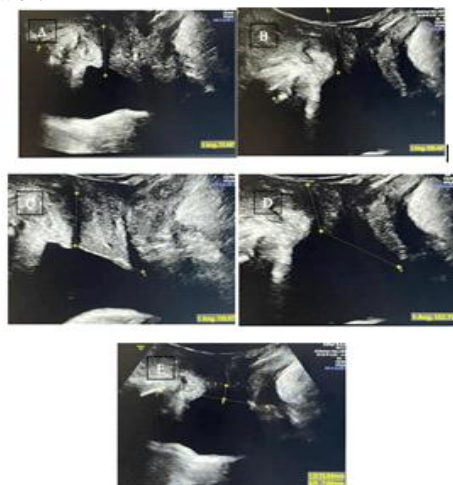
Transperineal ultrasonography (USG) in the midsagittal section. (A) Alpha angle at rest (73°). (B) Alpha angle during strain (102°). (C) Beta angle at rest (102°). (D) Beta angle during strain (132°). (E) The bladder descent during strain measured 7.89 mm from the reference line drawn between the pubic symphysis and anorectal junction, indicating cystocele.
